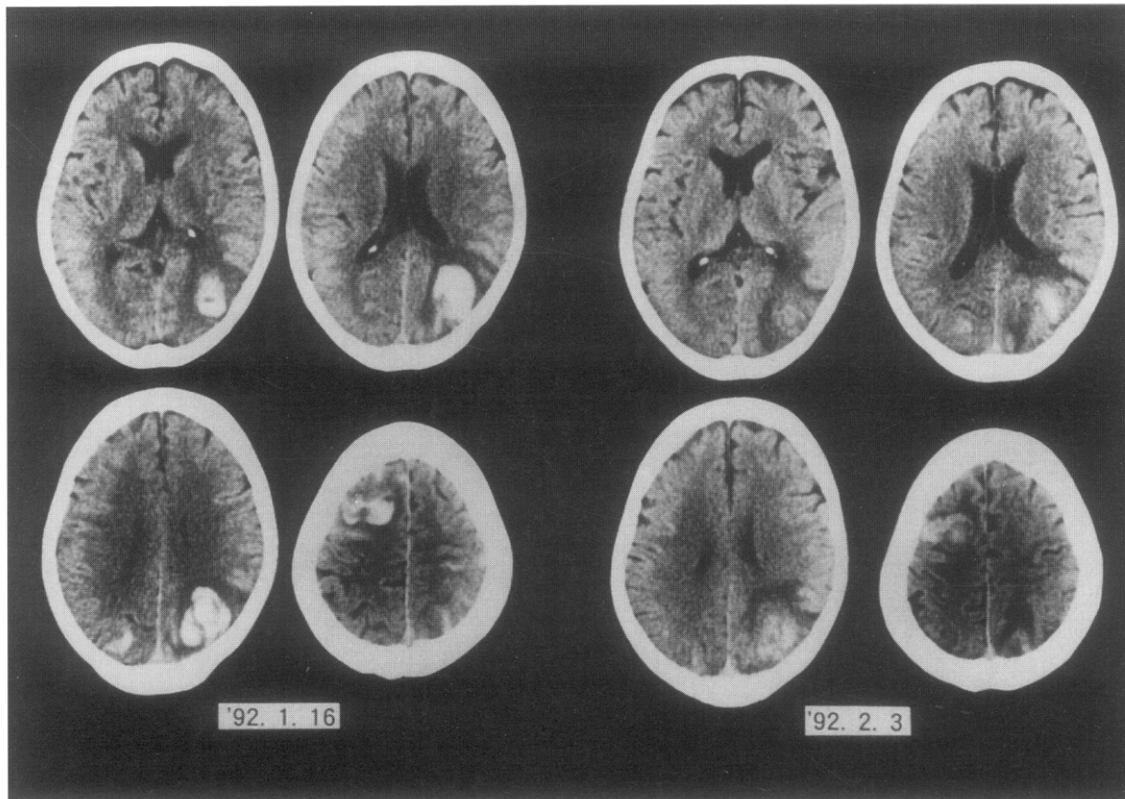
Computed tomographic scans of a patient with cerebral hemorrhage resulting from infective endocarditis. This patient underwent mitral valve rereplacement 15 days after cerebral hemorrhage without any complications. *Left*, Preoperative computed tomographic scan; *right*, postoperative scan.
